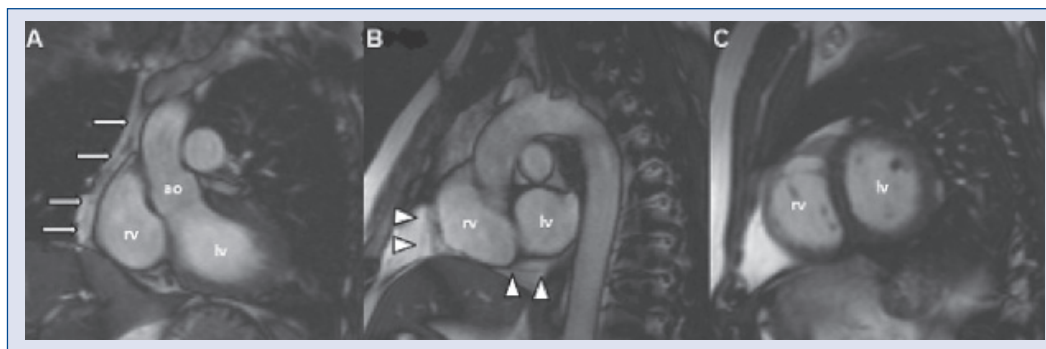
A. Left ventricular outflow tract view of cardiac magnetic resonance imaging (MRI) showing pericardium at periphery of right ventricle (arrows); B. Short axis MRI frames of heart base showing thin pericardium (arrowheads). C. There is no pericardium on midventricular frames; ao — aorta; lv — left ventricle; rv — right ventricle.
